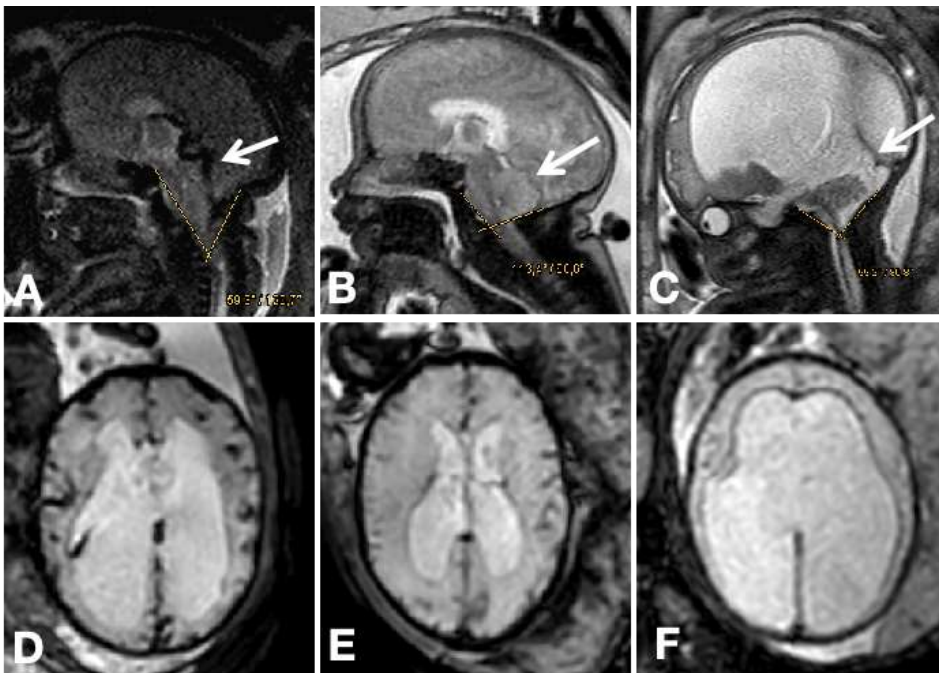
Comparison of clivus-supraocciput angle and venous changes among age-matched fetuses with Chiari II malformation with and without intracranial hemorrhage (ICH), and a fetus with aqueduct stenosis and ICH. A, D: Prenatal MRI scans of a fetus diagnosed with Chiari II malformation and ICH at GA35 weeks reveal congestion in the straight sinus(arrow) and cortical veins. A sharper clivus-supraocciput angle is depicted in (A). B, E: Remarkably, the same imaging modalities in a Chiari II fetus without ICH (at GA35+3 weeks) show a larger clivus-supraocciput angle without congestion in the straight sinus(arrow) and cortical veins, as seen in the ICH case. C, F: Prenatal MRI of a fetus with aqueduct stenosis and ICH performed at GA33 weeks depicts normal conditions of the straight sinus(arrow) and cortical veins. Noteworthy are the more rounded posterior horns compared to the distinct pointed posterior horns in the above two CM II cases.
